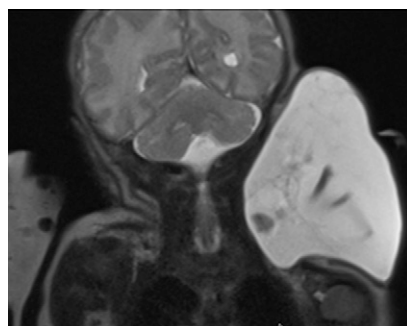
MRI of the neck, with contrast revealing a large cervical lymphangioma without impingement or involvement of the airway.
